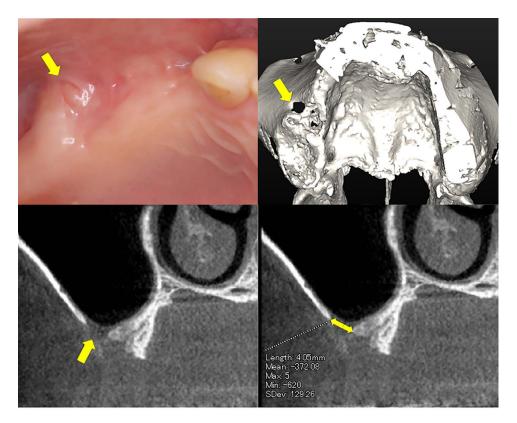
The arrow indicates the location of the fistula. 3D and cross-sectional images of the fistula area on CBCT. The fistula was approximately 4 mm in diameter.
